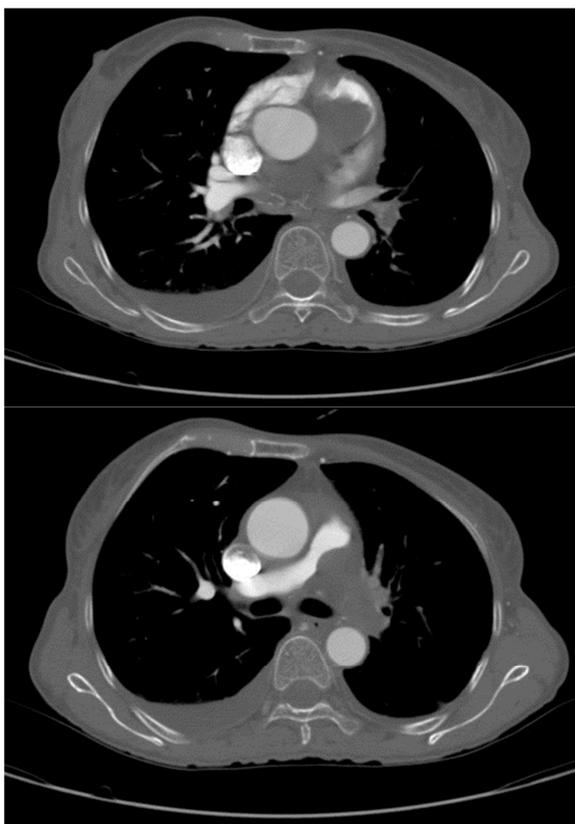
Magnetic resonance imaging reveals a polypoid lesion at the trunk of pulmonary artery with extension to left main and the first branch
